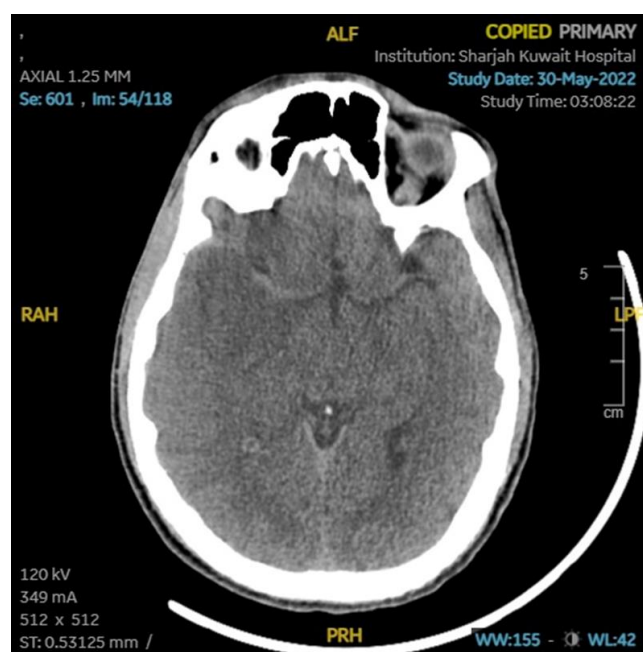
CT brain axial images showing hyperdense right middle cerebral artery
